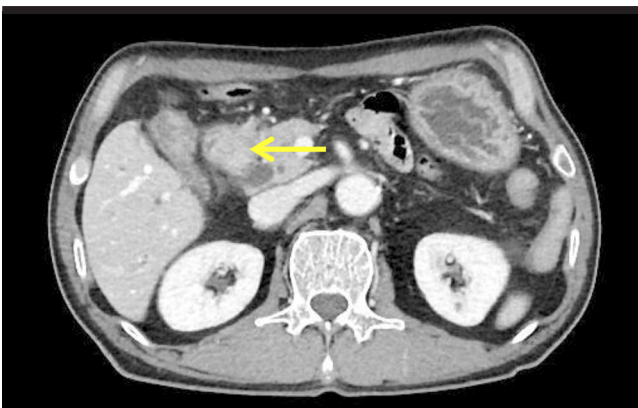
Abdominal computed tomographic scan with contrast enhancement shows focal thickening with prominent enhancement in the proximal second portion of the duodenum.
